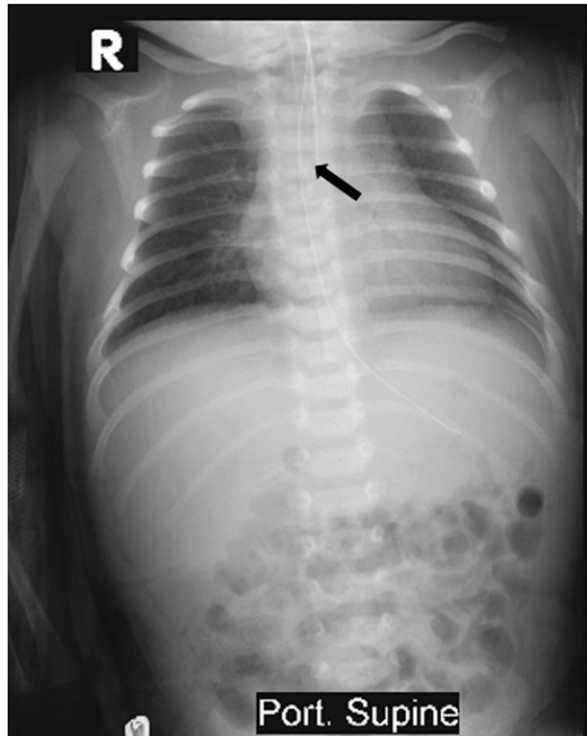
First chest radiograph with the patient receiving continuous positive airway pressure revealed proper lung inflation and no lung opacities.
